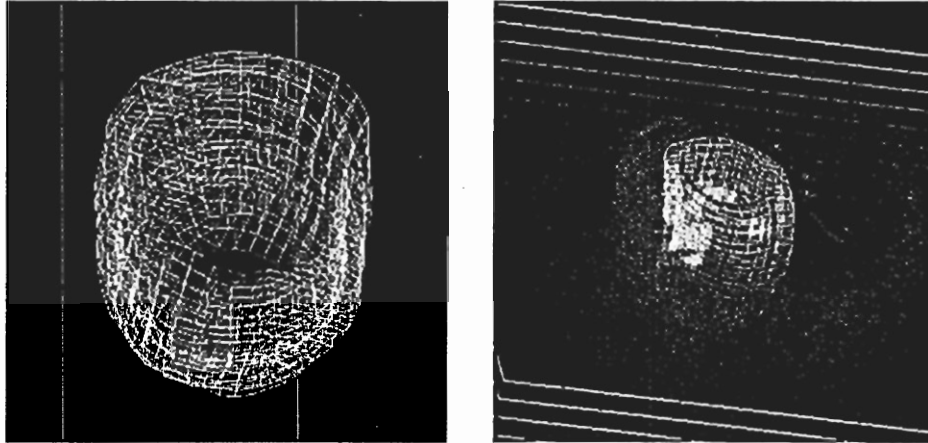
Examples of the mid-wall sample data points and a set of the entire three-dimensional sample data points. a) the mid-wall sample data points are superimposed on the segmented two-dimensional magnitude image. b) a stack of the mid-wall sample data points. c) a set of the entire three-dimensional sample data points. d) a set of the sample data points are superimposed on a stack of the two-dimensional magnitude images of phase contrast MRI.
